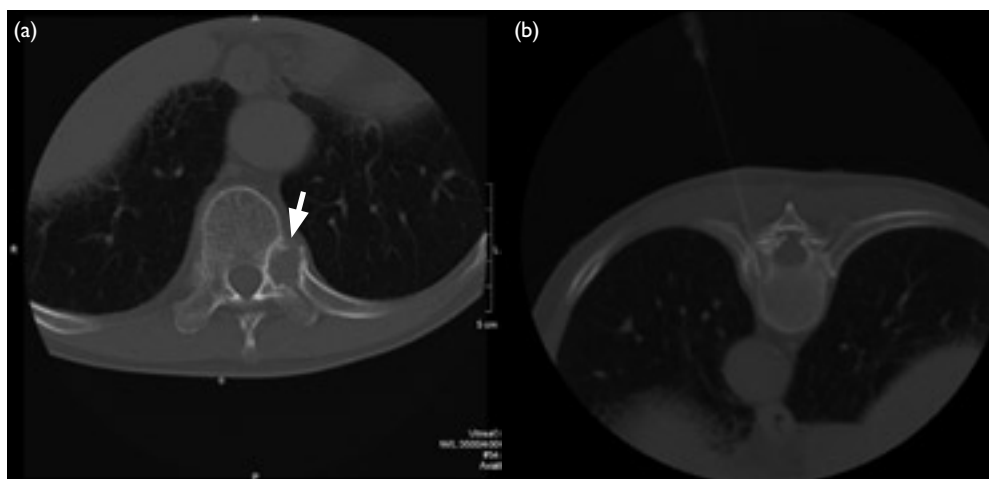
(a) Plain axial computed tomography (CT) of thoracic spine at T10 level shows a well-defined non-calcified lytic lesion in the left pedicle of T10 (arrow). (b) Plain axial CT shows biopsy needle in situ
